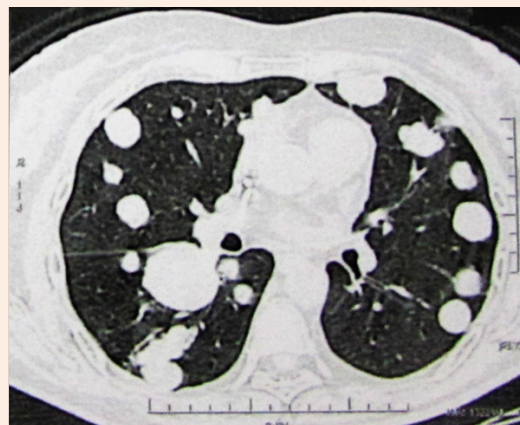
Chest CT scan showing bilateral increase in pulmonary nodules.
